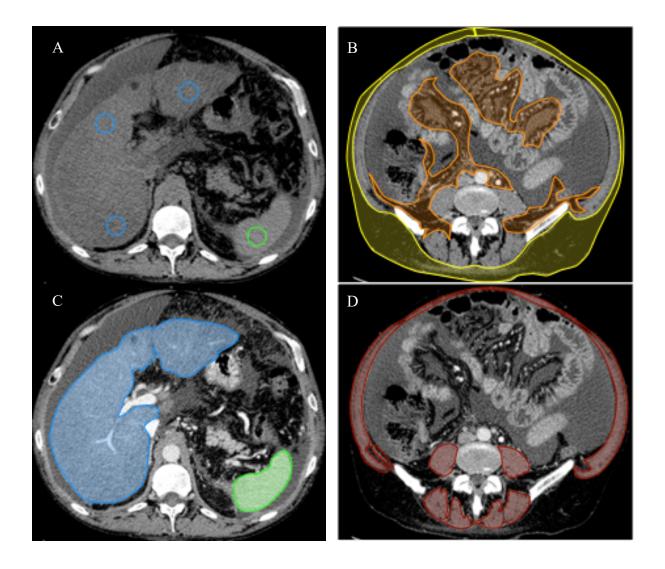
Computed Tomography images showing, A regions of interest (ROI), three into the liver and one into the spleen. These ROIs are used to measure the attenuation coefficient which is correlated to the liver fat content. B Semi-automatic volumetry calculation of the subcutaneous and intra-abdominal fat. C An example of the volumetry of the liver and spleen and D volumetry of the muscle mass
